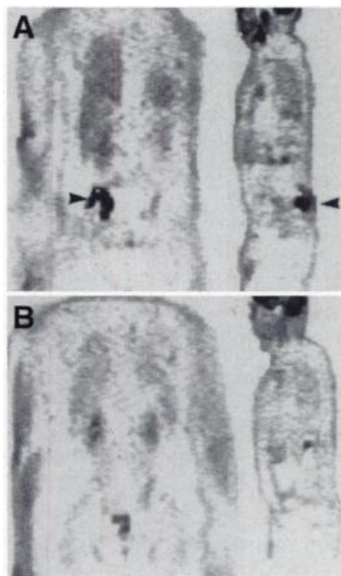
A patient with marked increased uptake of FDG in the right sacroiliac joint due to non-Hodgkin's lymphoma (indicated by arrowheads) immediately before treatment (A) and after treatment with chemotherapy (B).
